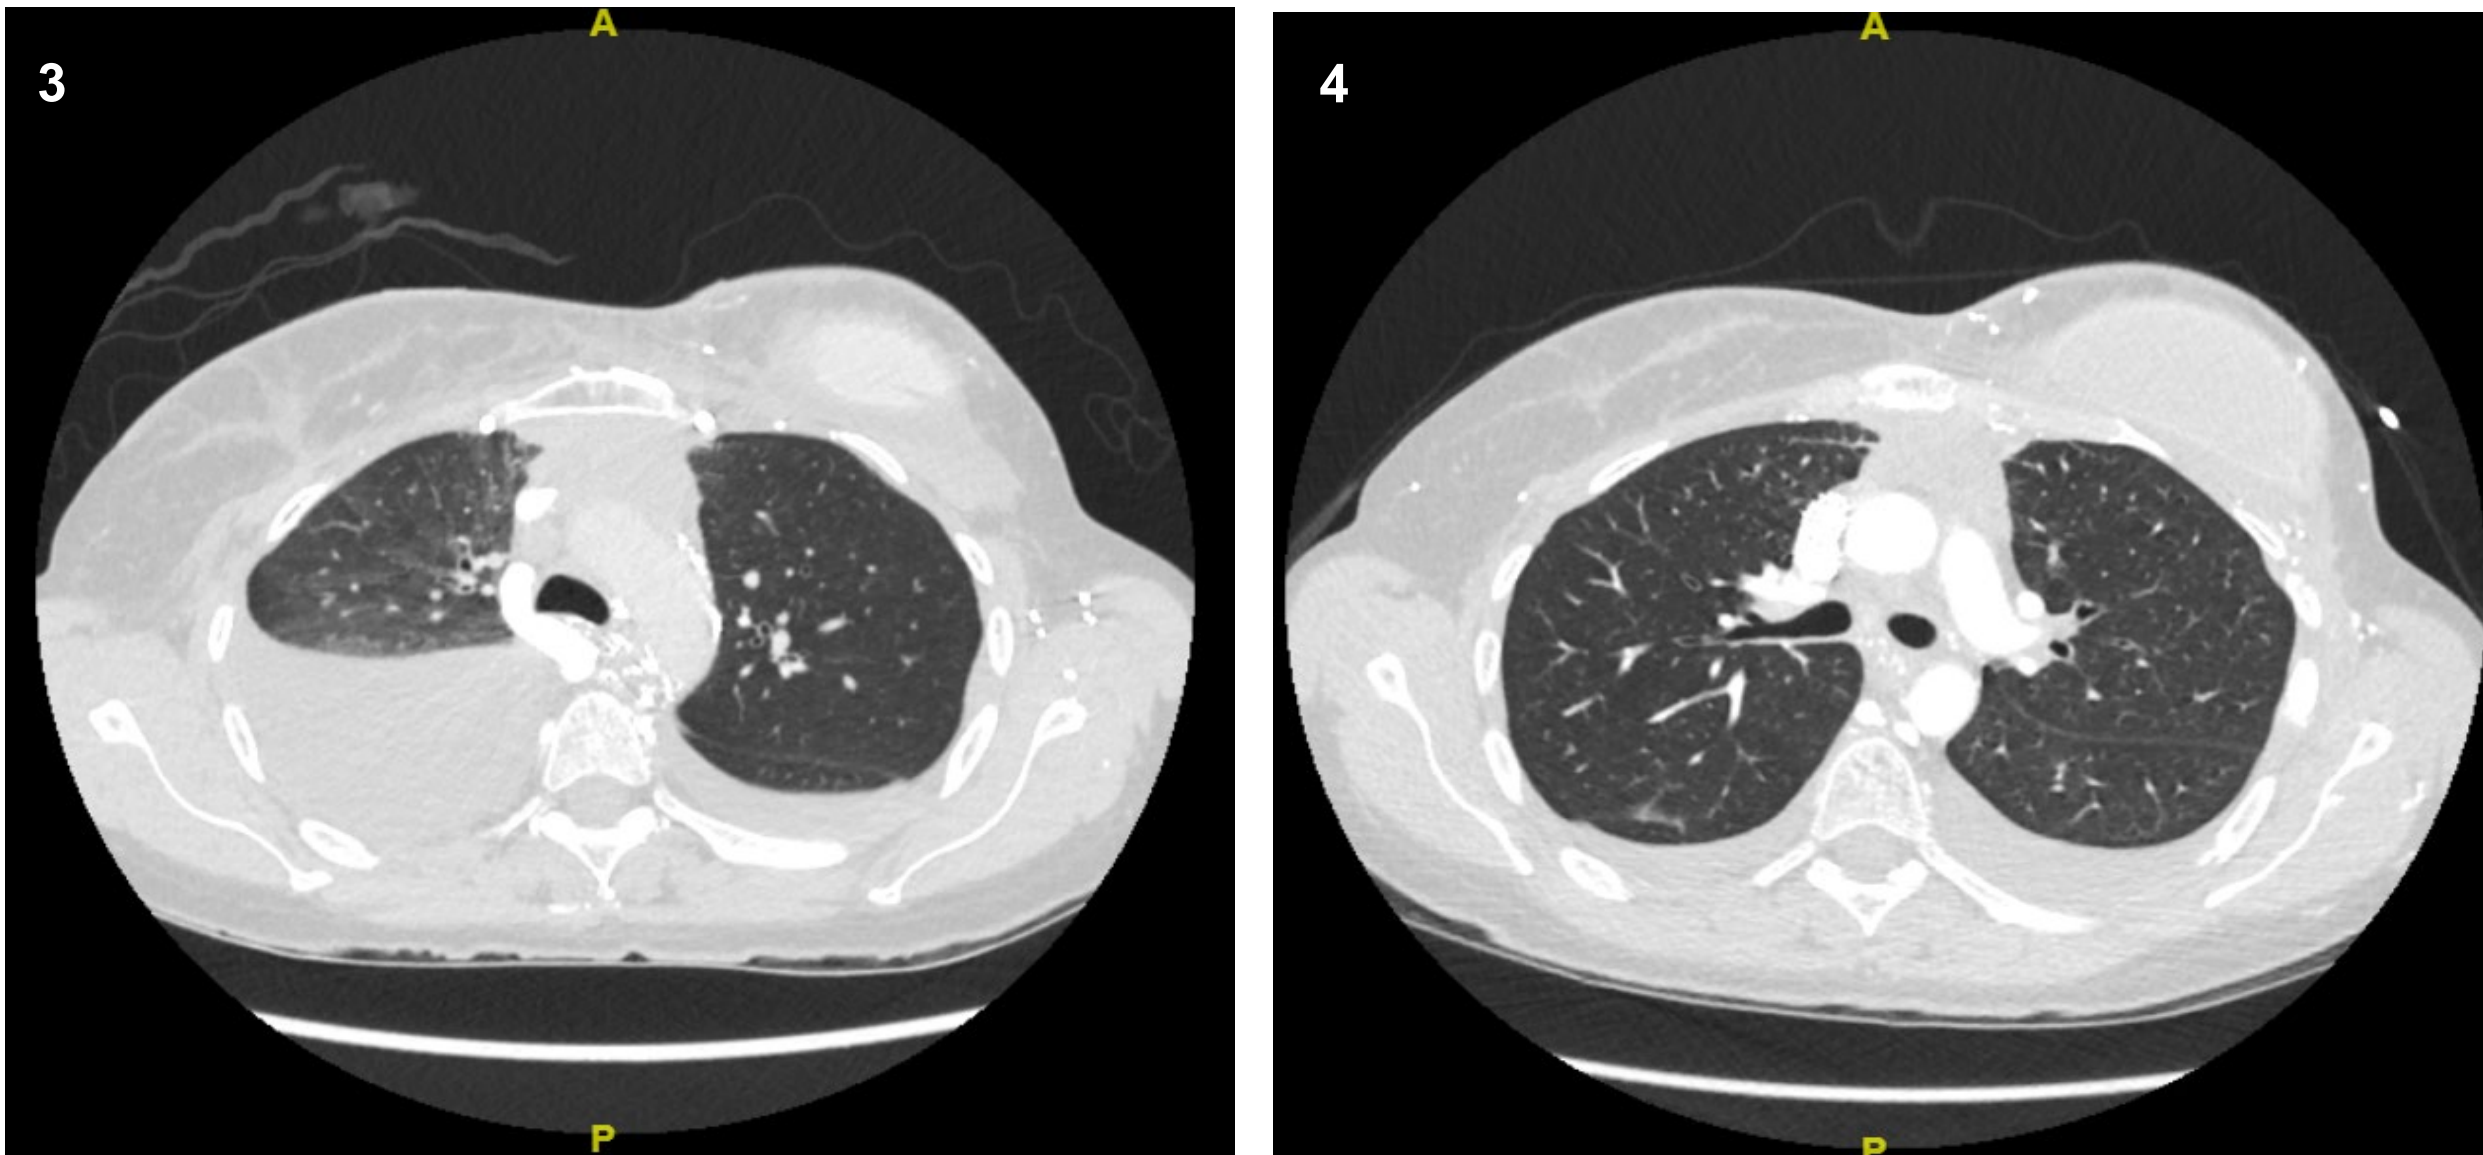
CT scan with right side chylothorax and small left side pleural effusion. Figure 4: CT scan with resolution of chylothorax after pleural catheter.
